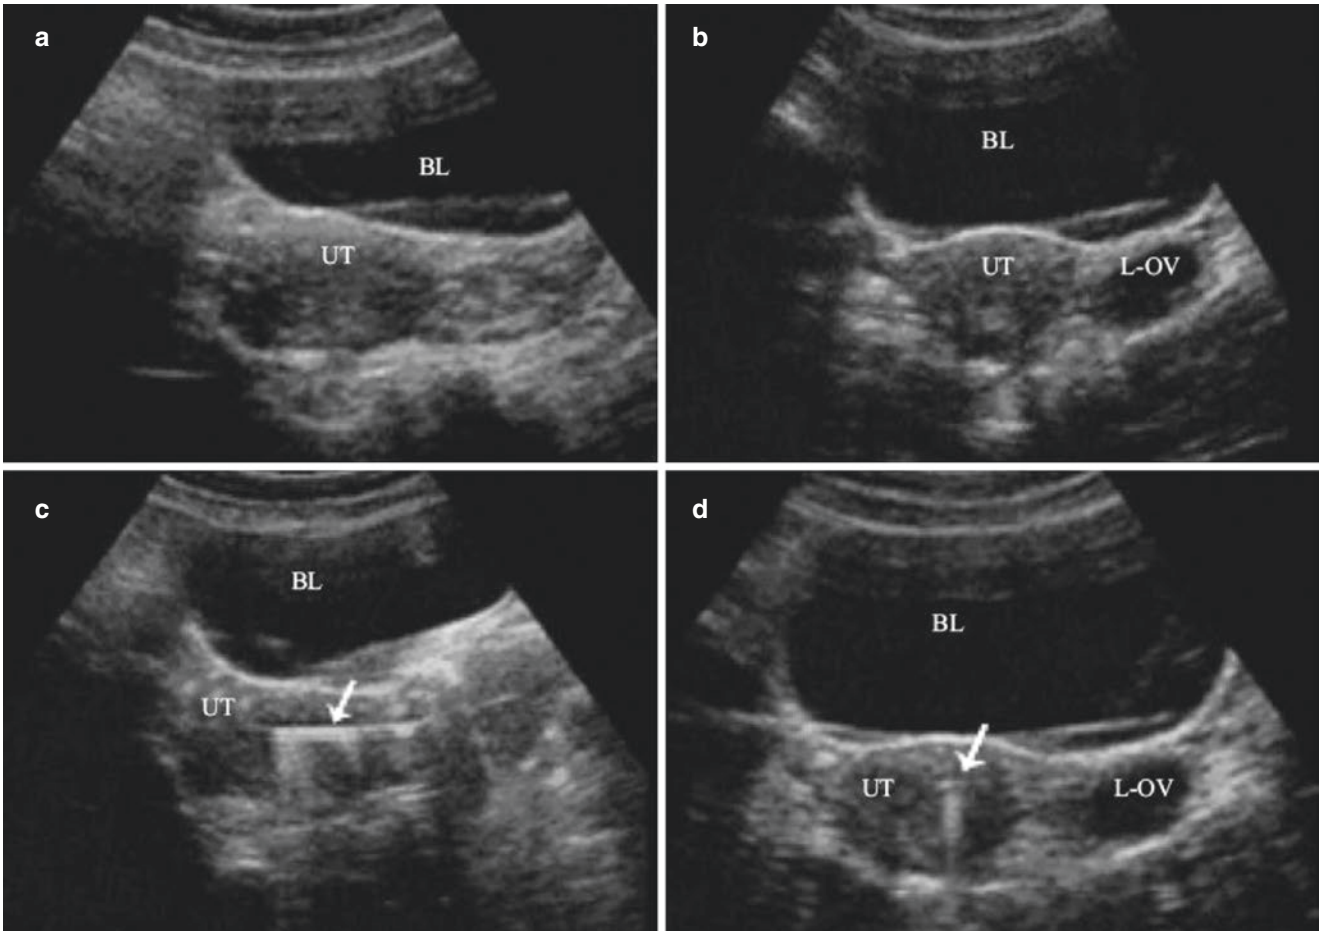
Sonogram of ultrasound monitoring during intrauterine surgery. (a) Before the surgery, the sagittal view of the uterus. (b) Before the surgery, the transverse section of the uterus. (c) During the surgery, in the sagittal view of the uterus, there are hyperechoic bands, followed
